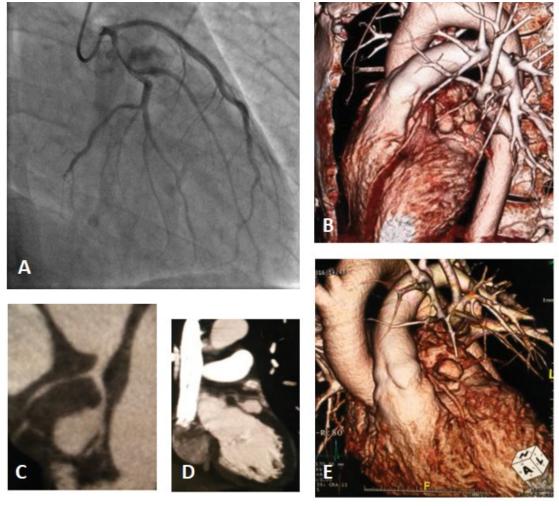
Circumflex artery aneurysm discovered in angiography and CT scan.
